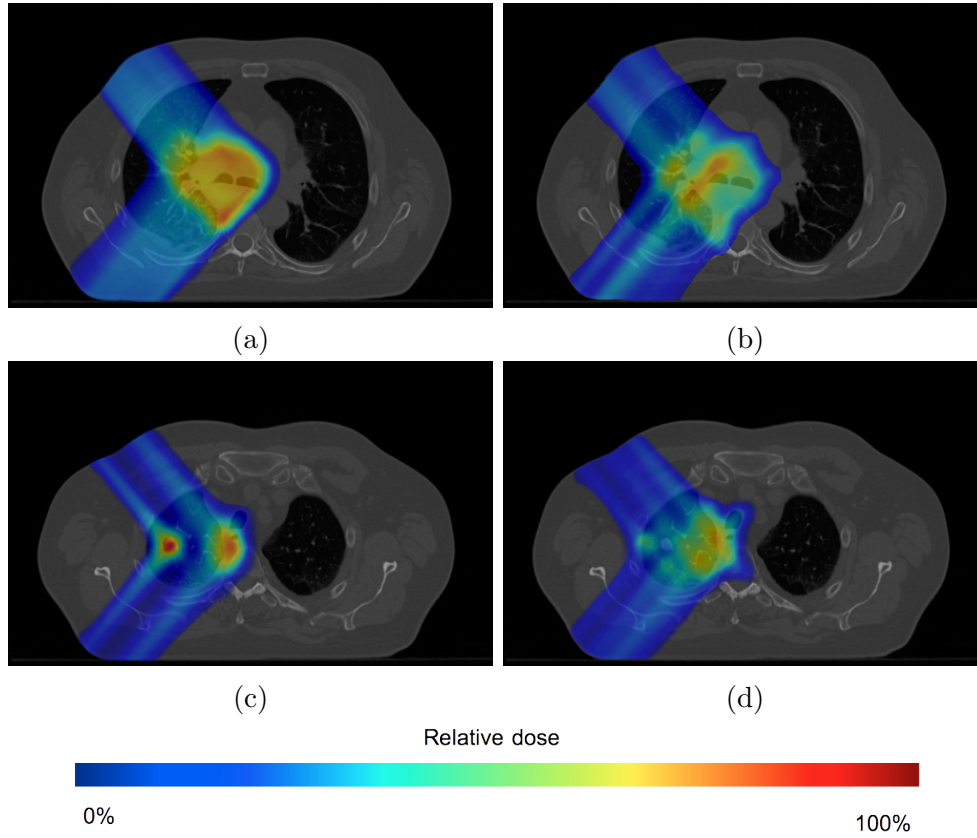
Dose distributions computed overlaying a patient CT image (transverse planes), for a static (4.14a, 4.14c) and a moving patient (4.14b, 4.14d). Slices 4.14a and 4.14b are located near the middle of the tumor and slices 4.14c and 4.14d are located near a border of the tumor.
